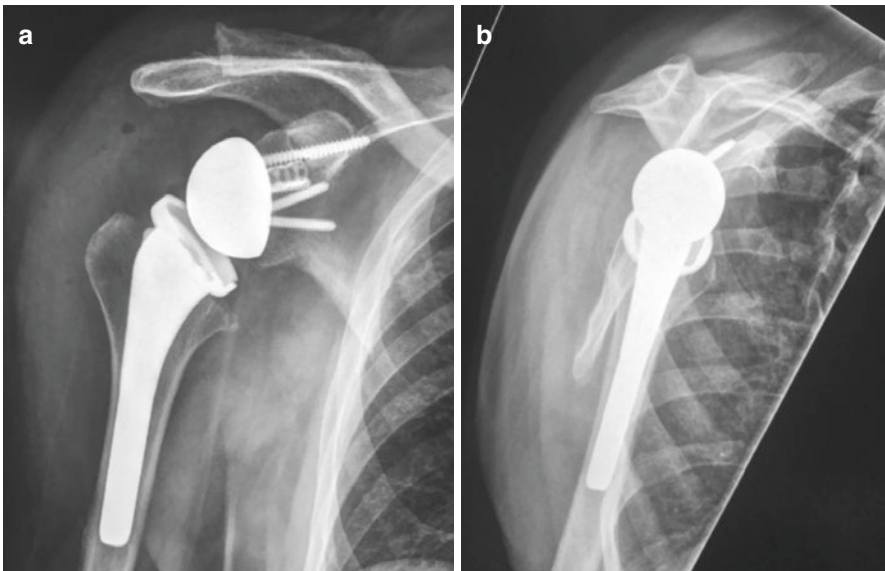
X-rays showing total shoulder arthroplasty
